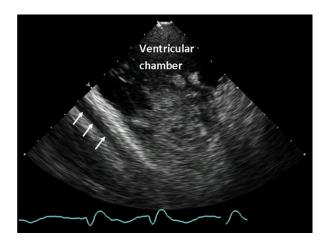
Intracardiac echocardiogram (ICE) image showing the intraprocedural identification of an enlarging pericardial effusion (arrows) which allowed prompt management.
